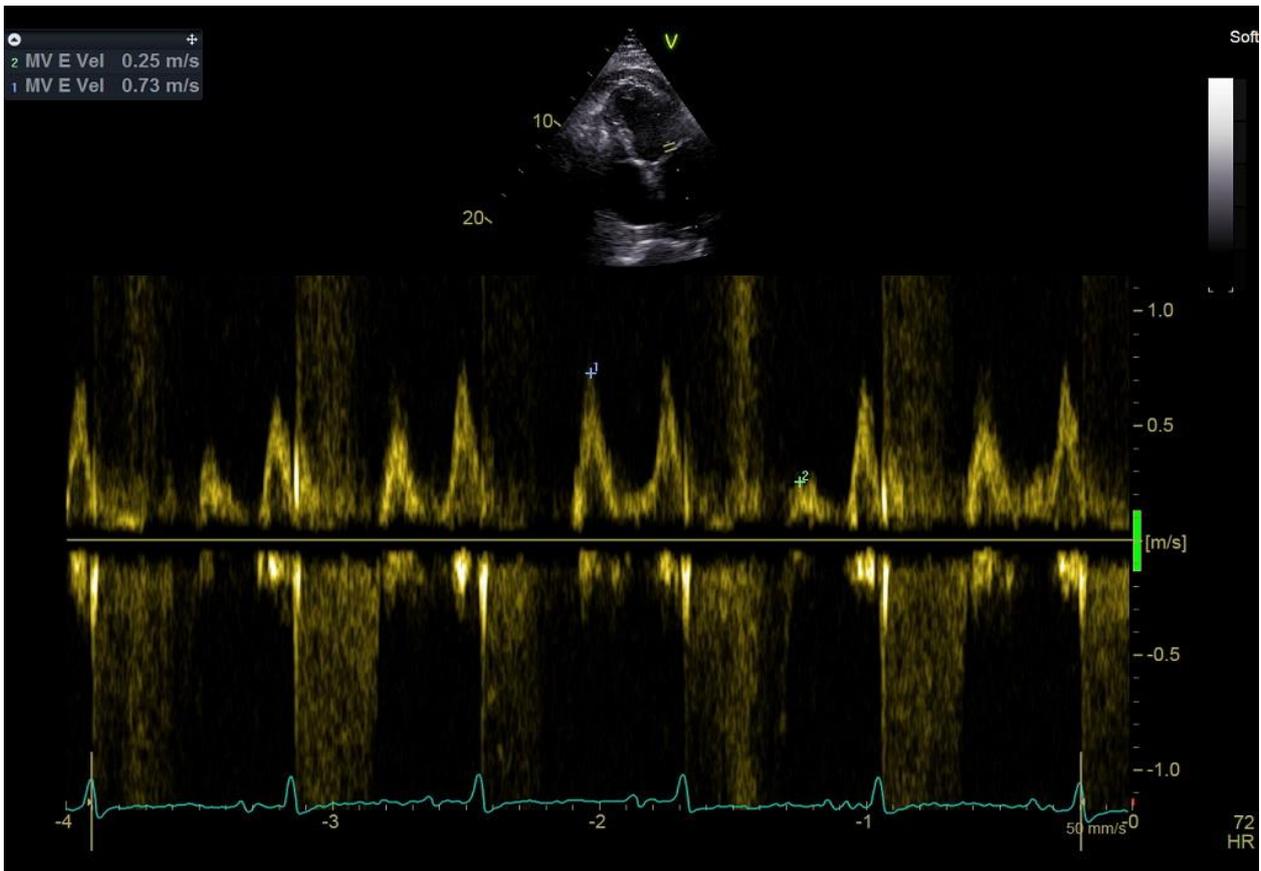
Transthoracic echocardiogram showing the significant respiratory transmitral Doppler variation (63% decrease in mitral inflow during inspiration).
